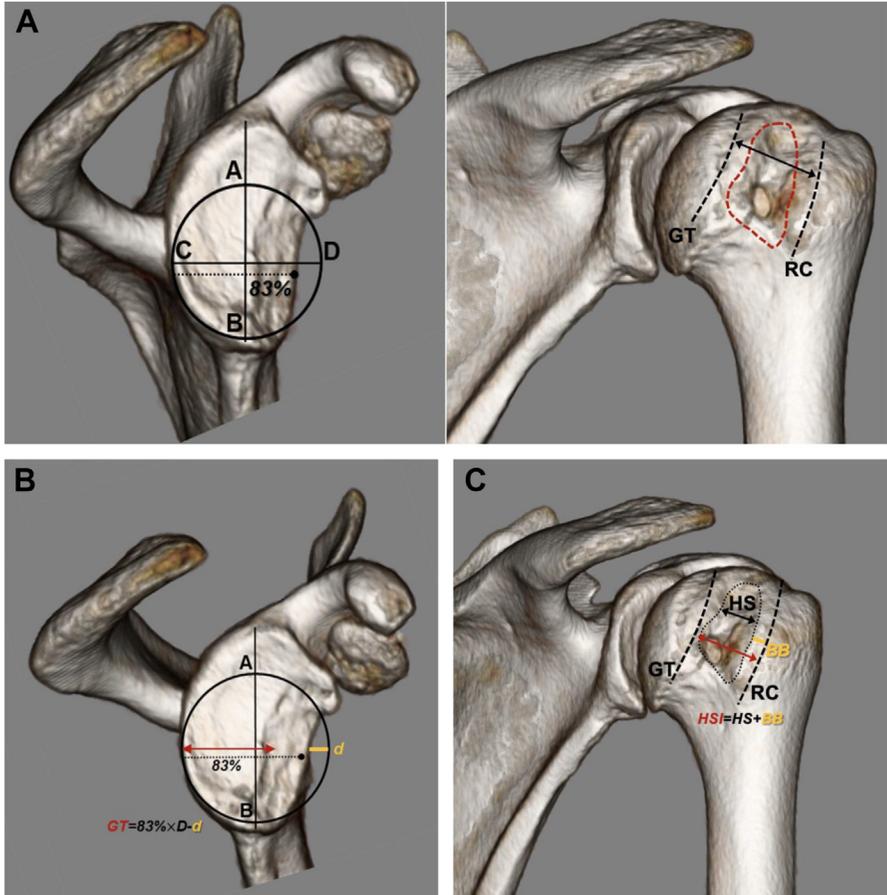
A 3D CT scan utilized to measure GT in the presence of an HS lesion. (A) Three-dimensional CT scan with en face views of a left shoulder with glenoid bone loss (left) and posterior humeral head with a medium HS lesion (right). Line A-B represents the long axis of the glenoid, and the perpendicular line C-D is the diameter of the inferior glenoid. The width of a normal GT is defined as 83% of the inferior glenoid width (*dotted line*). Dotted line GT indicates the medial margin of the GT; dotted line RC indicates the medial margin of the posterior rotator cuff attachments. The boundary of the HS lesion is outlined in the red-dotted circle. (B) Three-dimensional CT scan with en face view of a left shoulder glenoid with bone loss of width d (*yellow line*). With glenoid bone loss, $GT = 0.83 \times D - d$. D represents the inferior glenoid width of a normal glenoid without bone loss; line A-B is the long axis of the glenoid. The width of a normal GT without bone loss is defined as 83% of the inferior glenoid width (*dotted line*). (C) Three-dimensional CT scan with en face view of a left posterior humeral head with an HS lesion. The HSI is defined as the width of the HS lesion (boundary outlined in the red-dotted circle) plus the width of the intact BB between the HS and the posterior rotator cuff (RC) attachments. Dotted line GT indicates the medial margin of the GT; dotted line RC indicates the medial margin of the posterior RC attachments.
